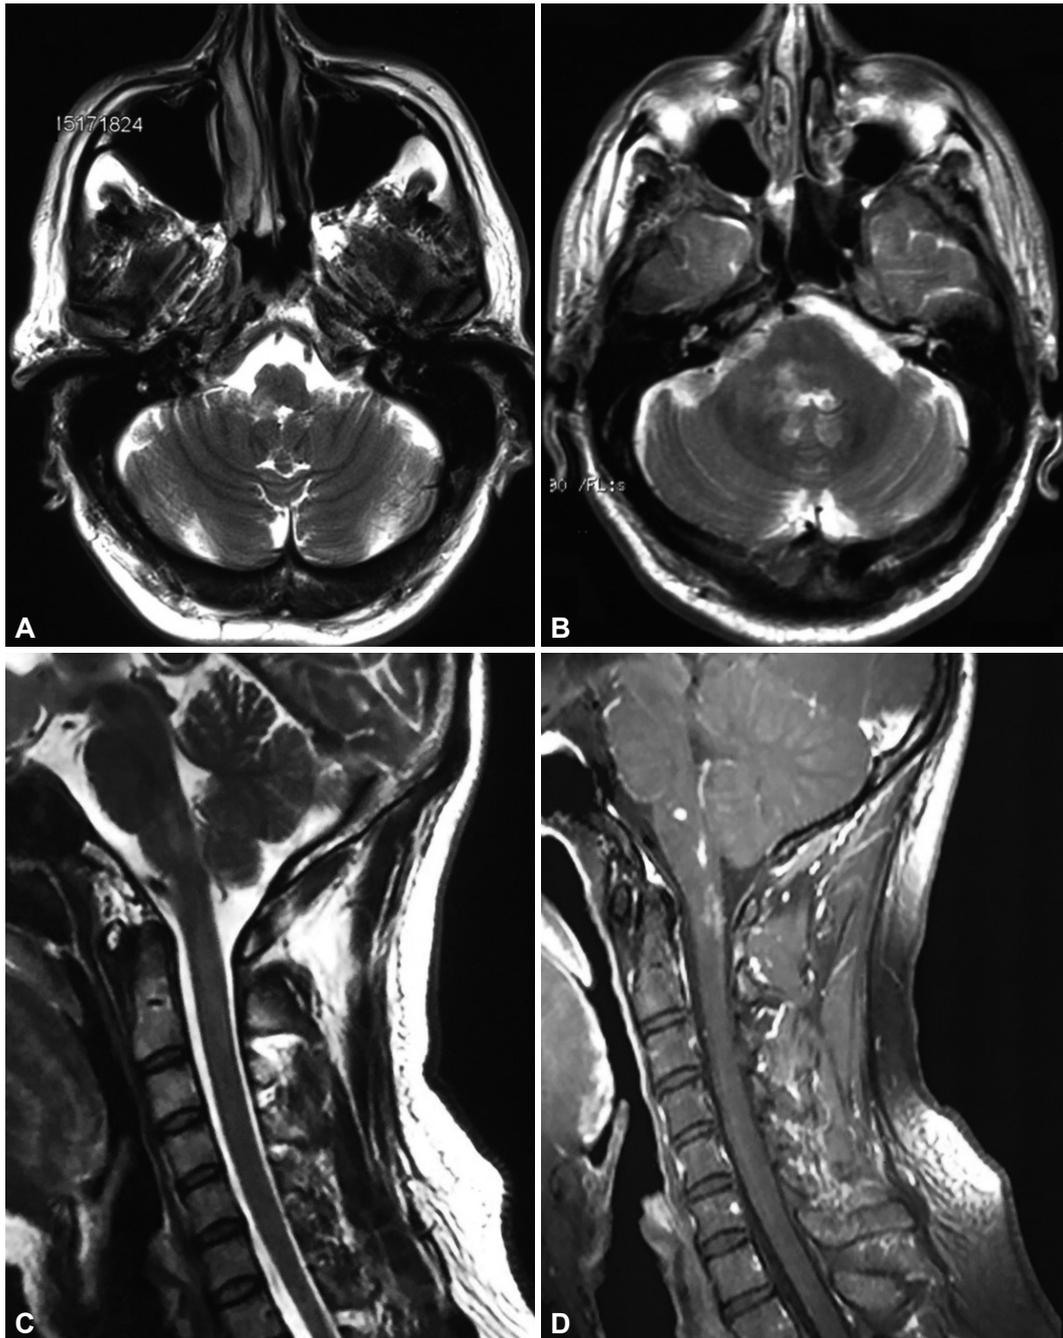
Cranial magnetic resonance imaging of Case 1 (A and B) and Case 2 (C and D). A and B: Axial T2-weighted images showing irregular patchy hyperintense areas predominantly in the right lateral medullary and pons, and also in the cerebellar pedunculus. C: Sagittal T2-weighted image showing multiple patchy and nodular lesions with T2 prolongation involving the brainstem and upper cervical spinal cord. D: T1-weighted post-contrast image showing multiple parenchymal nodular and ring-enhanced lesions in the brainstem and upper cervical spinal cord.
